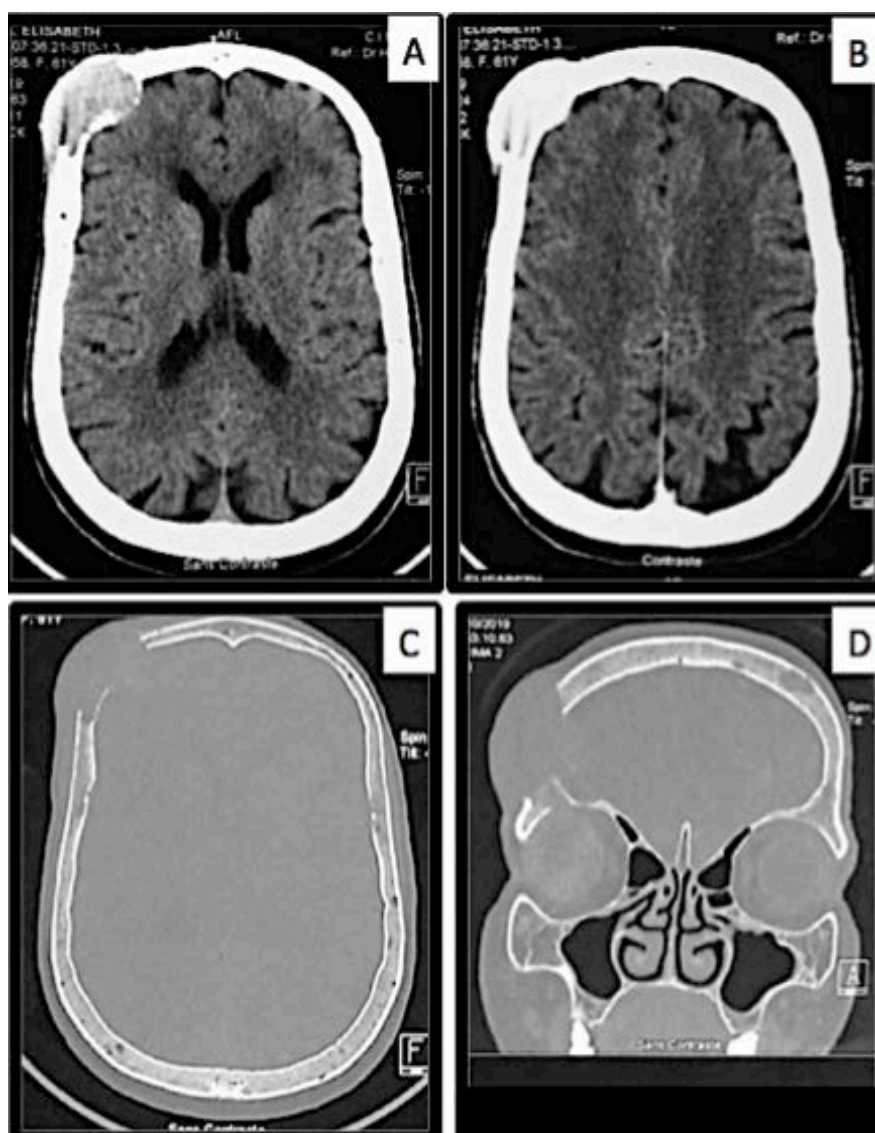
(A) Preoperative CT Scan showing a right intraosseous frontal process; (B) With intense enhancement on post-contrast images; (C) And osteolysis on bone slices; (D) There is also a left frontal intradiploic lesion.
